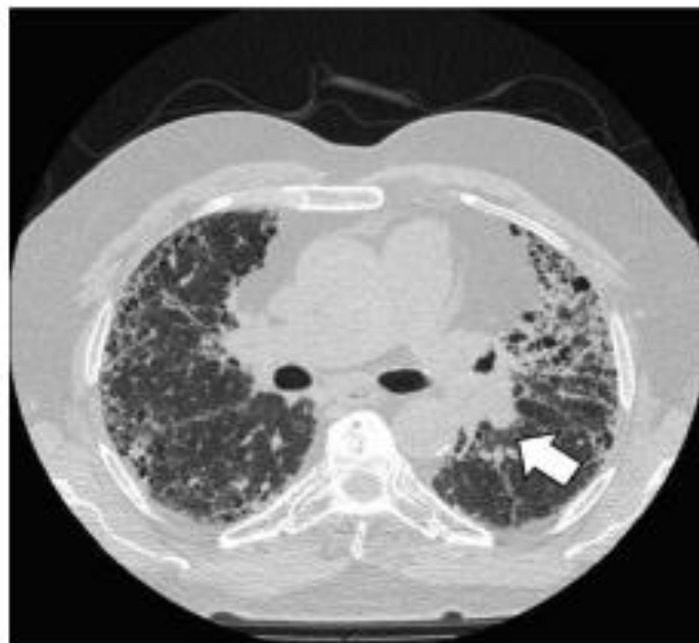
CT scan of a 69-years-old male with IPF and squamous cell carcinoma.
